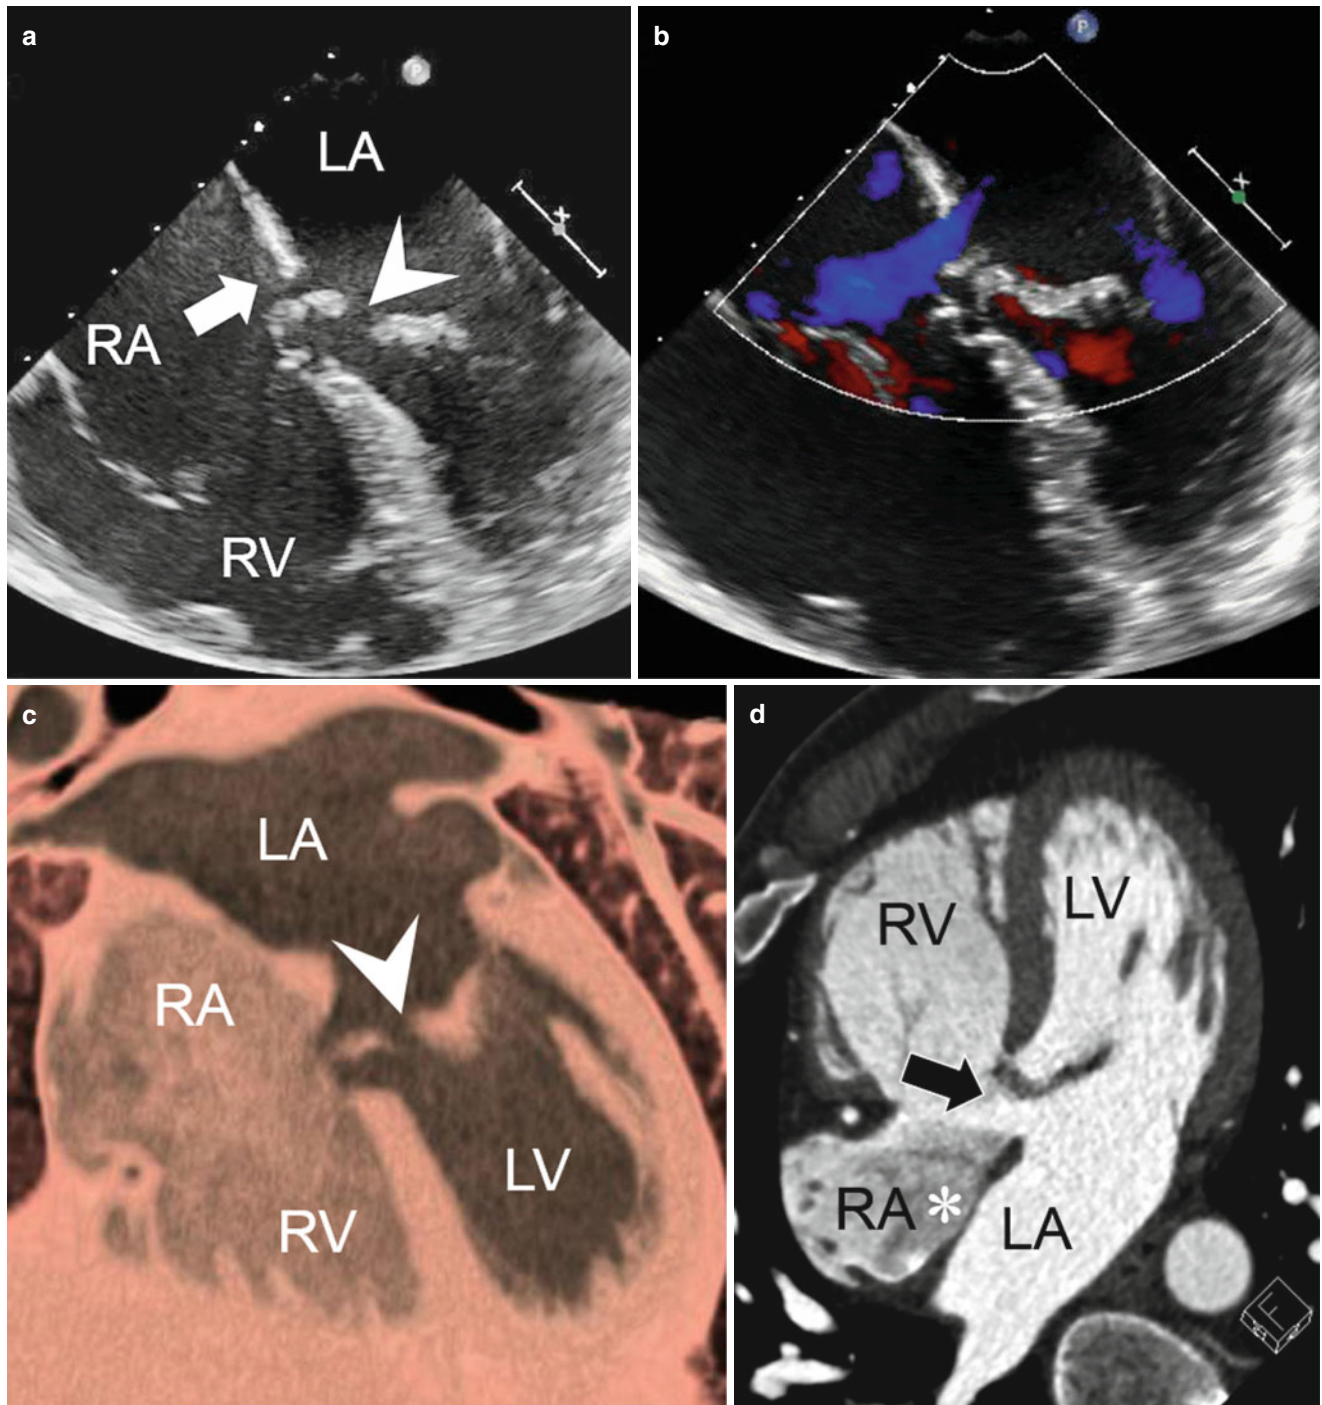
Mitral valve cleft with primum type of atrial septal defect. (a, b) Transesophageal echocardiography (b, color Doppler movie clip) shows an atrial septal defect (ASD) of primum type (arrow) and mitral valve cleft (arrowhead). (c) Oblique axial volume rendering CT image shows
